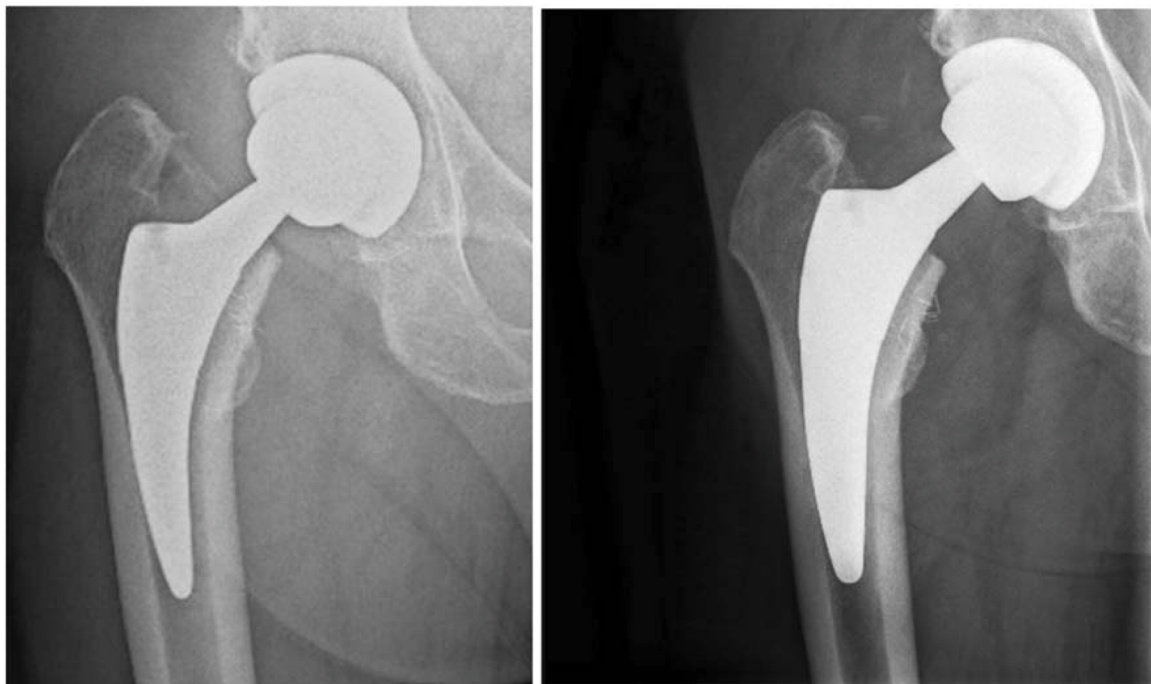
Revision of an aseptic early loosening of a Fitmore® femoral stem using a new Fitmore® stem for revision. Preoperative radiograph (left) showing an aseptic loosening of a Fitmore B4-EXT femoral® stem in a right total hip arthroplasty. Post-revision radiograph (right) demonstrating successful reimplantation with a Fitmore® B8-EXT femoral® stem. At 7-year follow-up, the revision stem remained well-positioned with no complication or sign of loosening.
